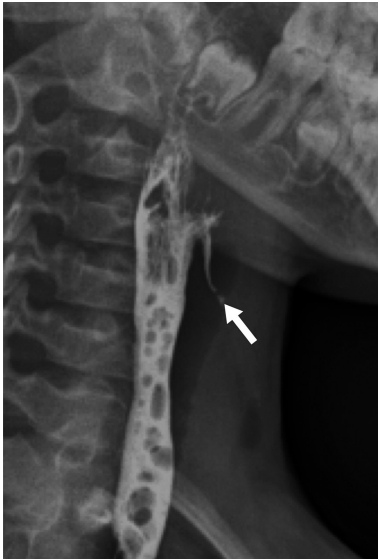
After drainage of the neck abscess, on postoperative day 7, neck US control showed a small residual pocket supposedly in communication with the hypopharynx. Barium swallow x-ray examination confirmed the suspicion of pyriform sinus fistula. US, ultrasound.
